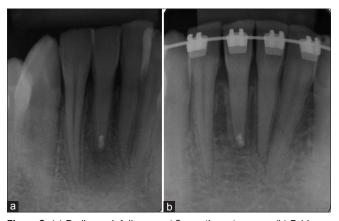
(a) Radiograph follow-up at 2-month postsurgery. (b) Evidence of periapical healing at 27-month radiograph follow-up
